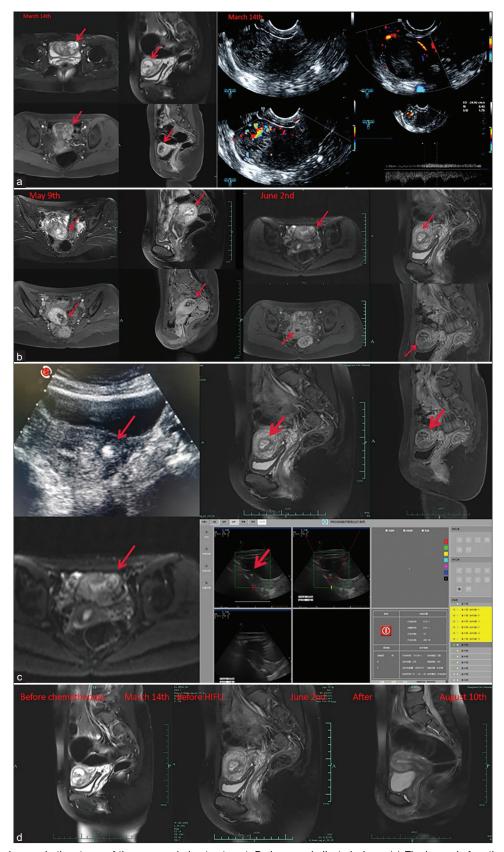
Imaging changes in the uterus of the woman during treatment. Red arrows indicate lesions. (a) The image before the treatment. (b) The image after chemotherapy and before high-intensity focused ultrasound. T2 shouws visible lesion approaching the serosal layer. (c) Images during the treatment process. The area with increased grayscale is consistent with the location of the magnetic resonance imaging (MRI) lesion. (d) The changes of uterus in the MRI during the treatment process. HIFU: High-intensity focused ultrasound
